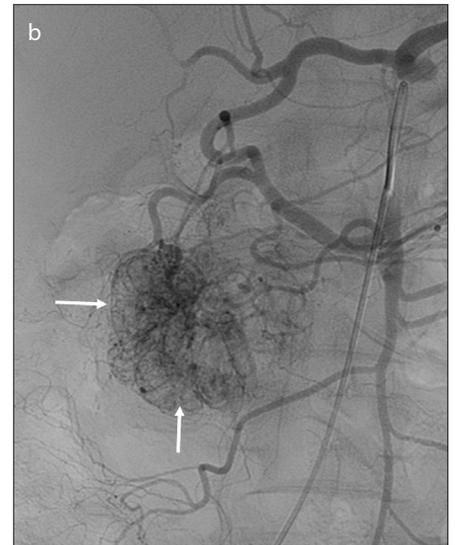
a, b. A 45-year-old woman with a duodenal GIST. Axial contrast-enhanced CT image (a) shows a very hypervascular soft-tissue mass (arrows) concentrated in the third portion of the duodenum. Arteriogram (b) shows that the main branches of the mass were coming from the inferior pancreaticoduodenal arch (arrows).
